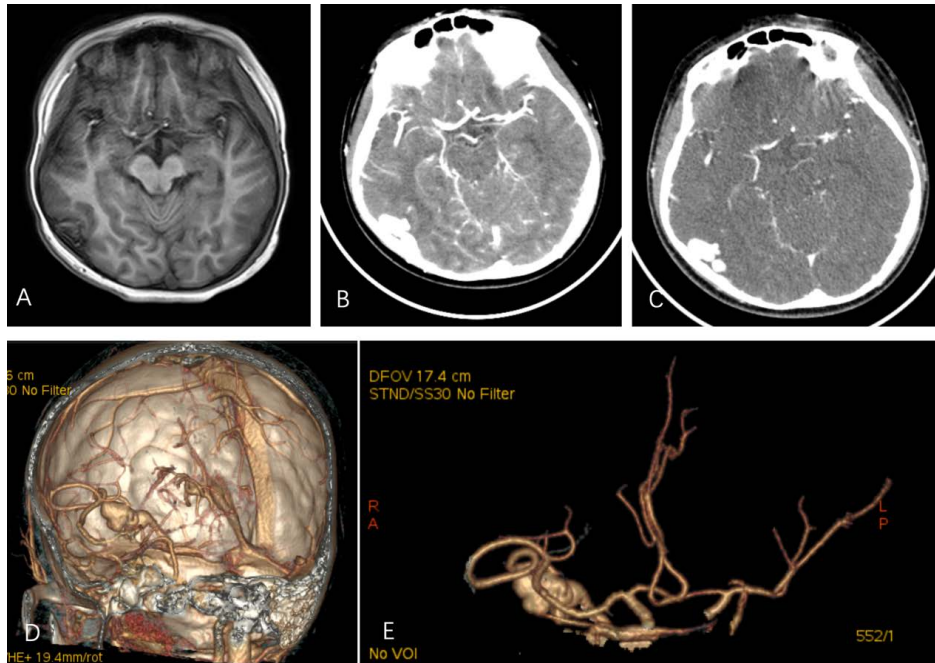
Cranial Contrast-enhanced CT and MRI: cerebrovascular malformation, right middle cerebral artery M2 segment branch-right transverse sinus, sigmoid sinus arteriovenous fistula.
